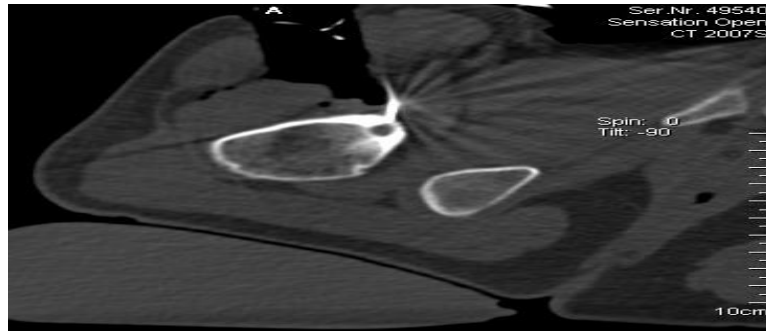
Case 3 Male, 18 years old, osteoid osteoma of proximal femur, 2017-2-21, intraoperative CT localization
